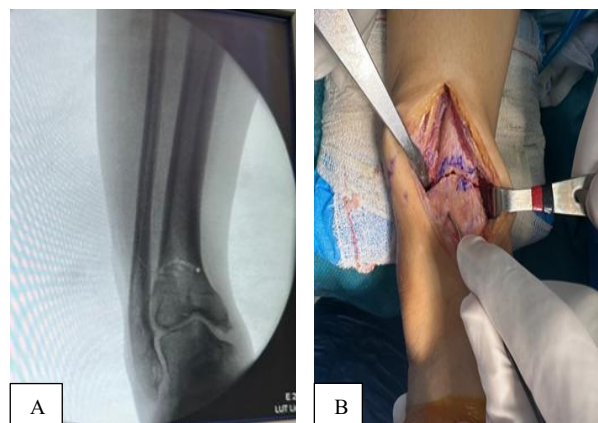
(A) intraoperative radiograph marking the osteotomy and (B) intraoperative photographs showing the osteotomy line.
